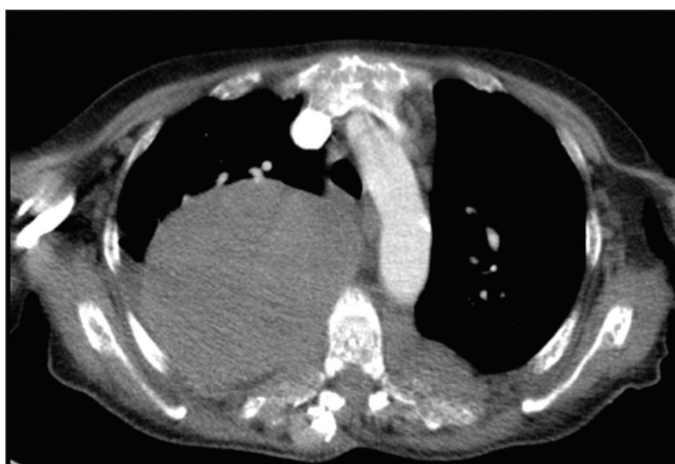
Thoracic computed tomography shows homogeneous mass with anterior-posterior diameter of approximately 100 mm and a lateral diameter of 110 mm in the right thoracic region.
